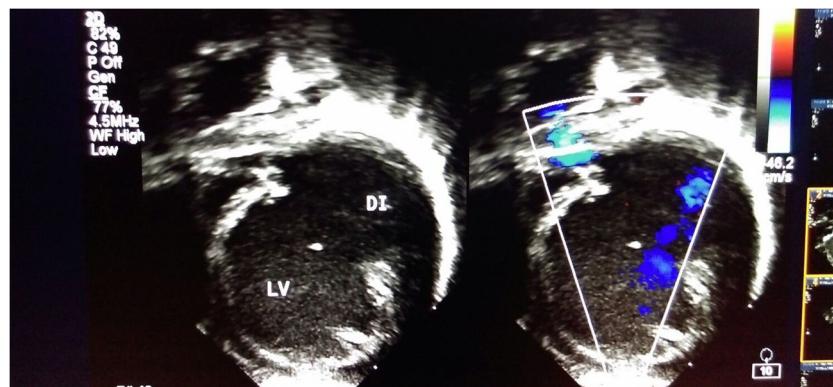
2D ECHO and colour doppler showing left ventricular diverticulum.
